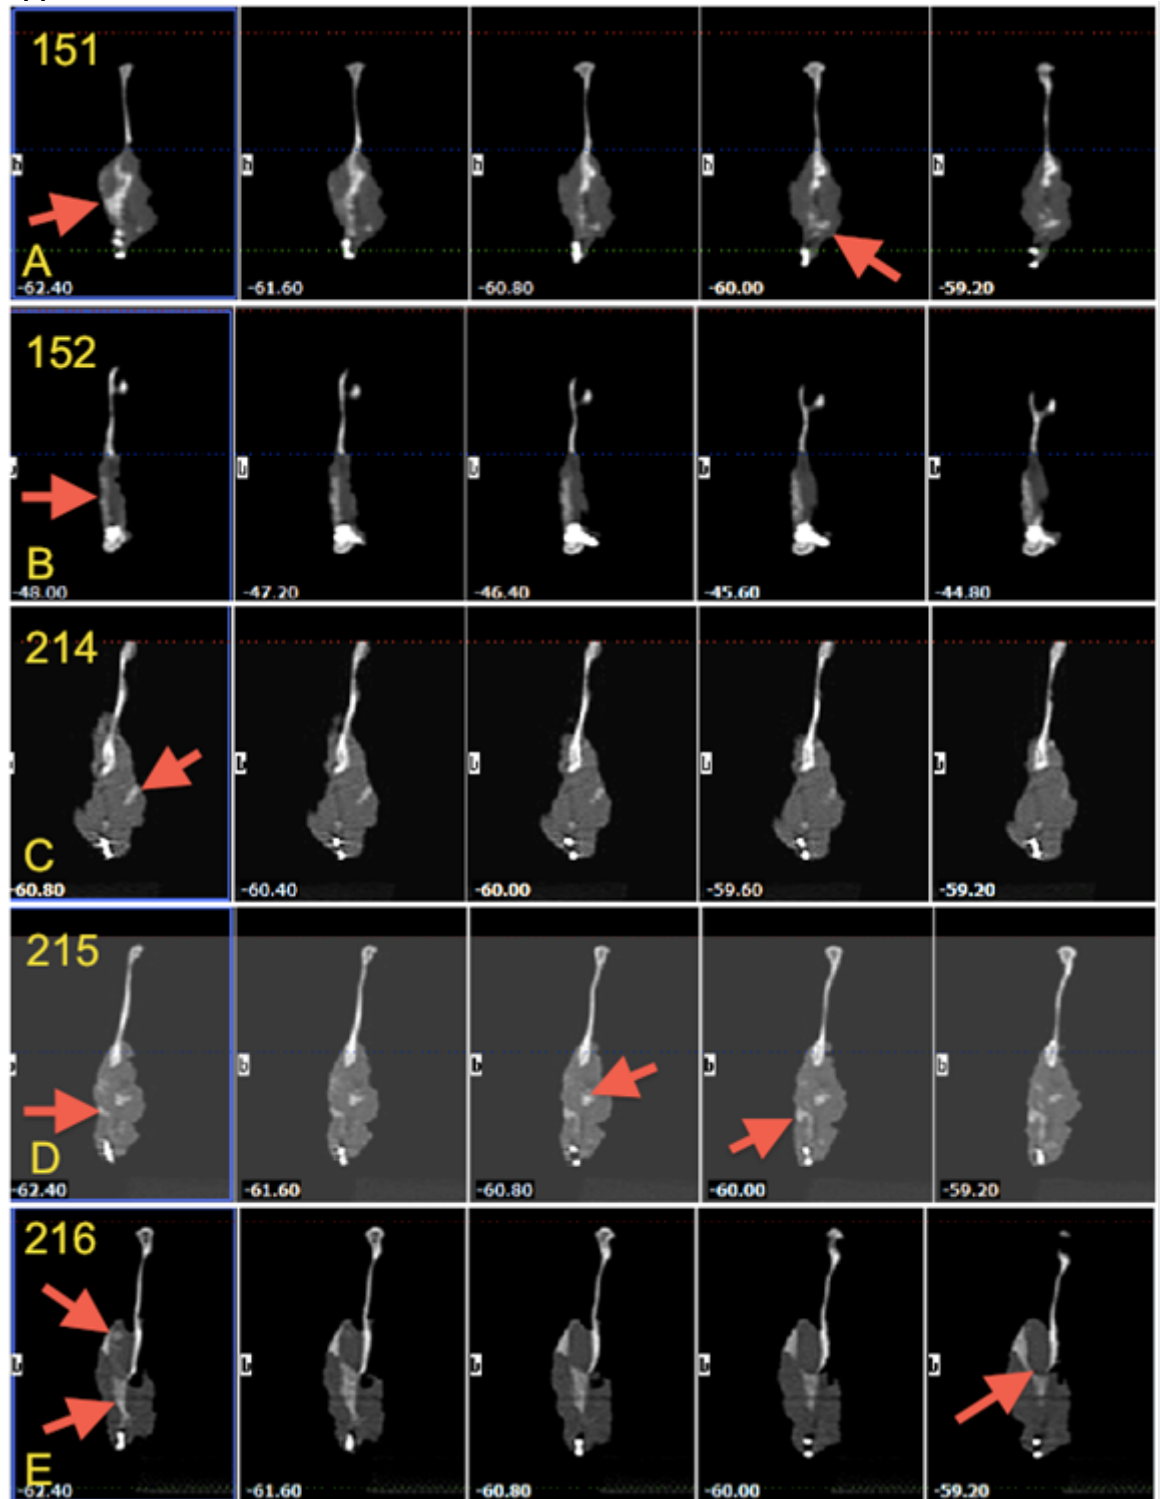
Consecutive CBCT coronal images for all cases involved in the main study, A) shows case 151 and the continuity of the regenerated tissue (arrow), the radio opacity was medial to the ramus, B) shows case 152 with the radio-opaque line (arrow) in line with the native bone, and a gap in the superior margin of the defect, C) shows case 214 with sporadic radio-opaque areas (arrow), and medially located, D) shows case 215, the radio-opaque tissues are continuous with the inferior border and displaced laterally (arrow), E) shows case 216 demonstrating a large bulk of radiopaque tissue (arrow) located lateral to the defect area, with no continuity with the inferior and superior border of the defect.
